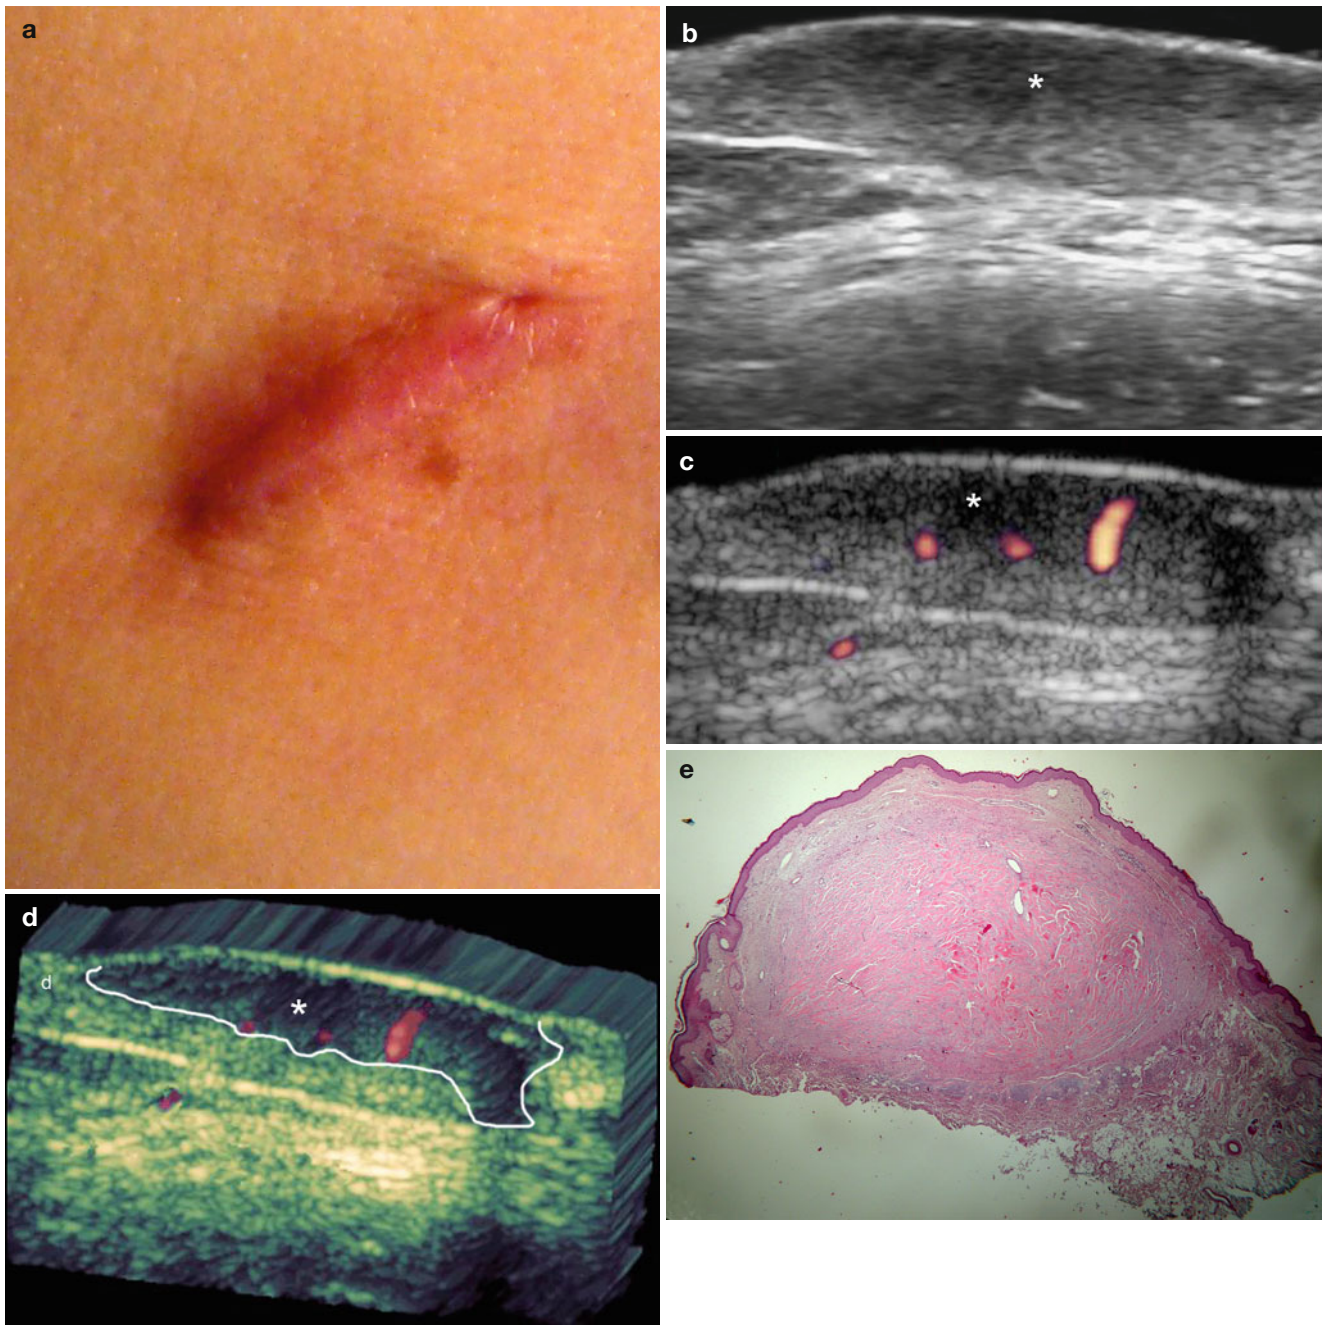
(a–e) Active keloid. (a) Clinical erythematous swelling in the left dorsal region. (b) Grey scale ultrasound image (transverse view) demonstrates a hypoechoic thickening (*) of the dermis with a fibrillar pattern. (c) Power angio Doppler ultrasound image (transverse view) shows increased blood flow within the lesion (*). (d) 3D power angio
